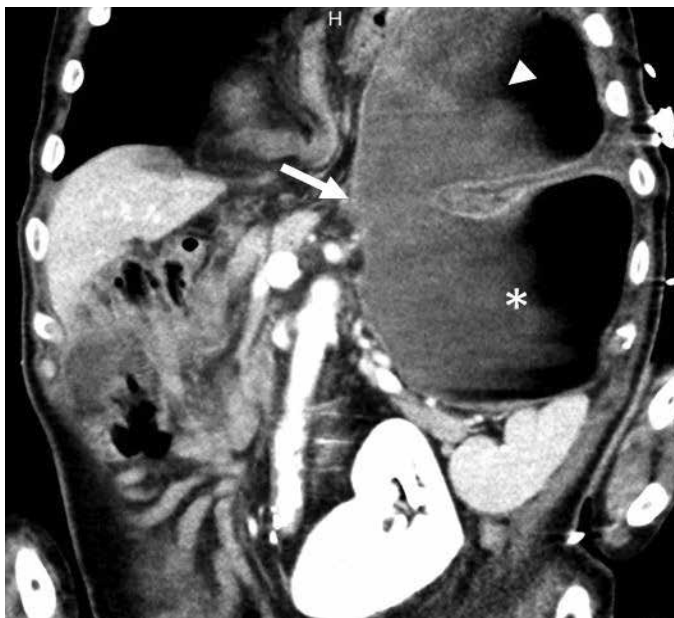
Coronal computed tomography multiplanar reformatted image demonstrates the displacement of the antrum above gastro-esophageal junction level (white arrow) with antrum and pylorus (arrow head located superior to the fundus and proximal body (*))
